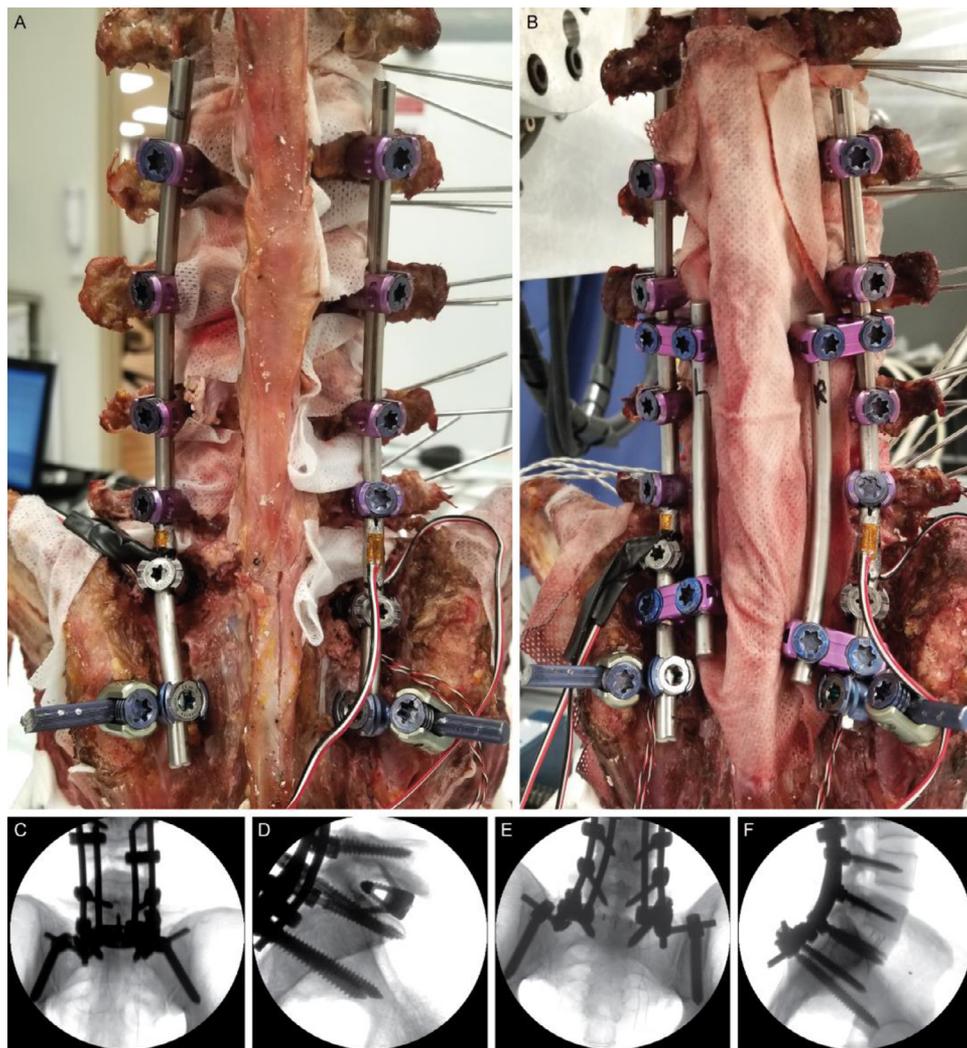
Two and 4R configurations of an L2-Ilium construct. (A) Demonstrates a 2R construct, with strain gauges attached between L5/S1, and bilateral S1 screws. (B) Demonstrates a 4R construct with an accessory rod attached with a side-to-side connector between L3/4 and S1/Ilium. Anteroposterior and lateral radiographs of anterior lumbar interbody fusion (C, D) and transforaminal lumbar interbody (E, F) constructs. Used with permission from (Institution blinded for review). 4R, 4-rod construction; 2R, 2-rod construction.
